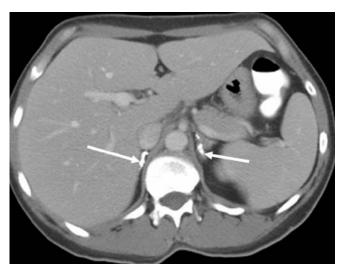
A 45-year-old male with a history of tuberculous and evidence of granulomatous disease on a chest radiograph. Axial contrast-enhanced CT image demonstrates bilateral moderately thickened adrenal calcifications, presumably secondary to previous tuberculous infection
